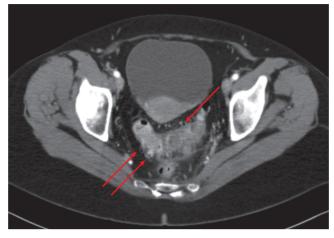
Diverticulitis. Axial contrast-enhanced CT shows inflammatory stranding in the fat surrounding multiple diverticula in the sigmoid colon. (Reproduced with permission from USMLE-Rx.com.)
